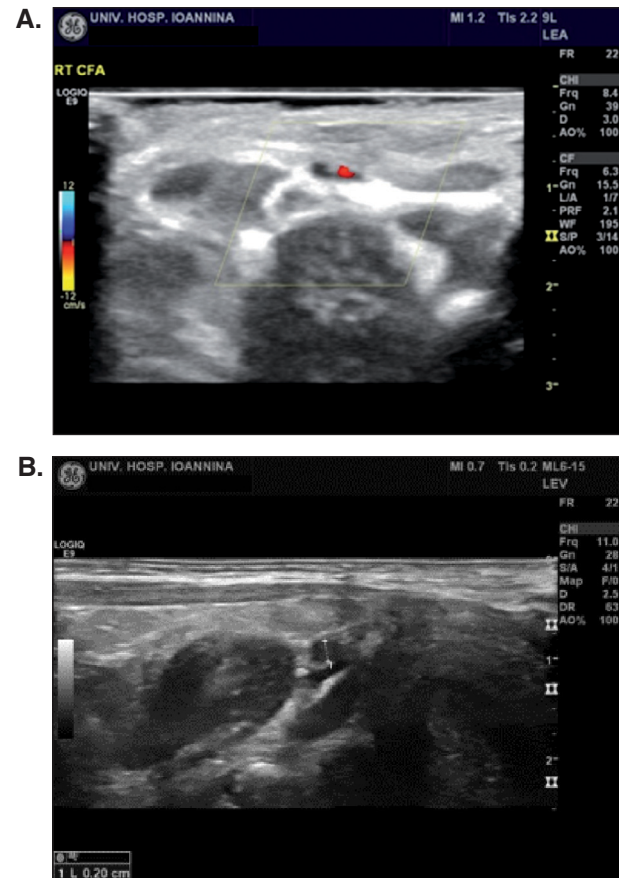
Sonographic images of neonatal femoral artery thrombosis. A. No blood flow in the right common femoral artery (CFA). B. Clot at the right CFA causing a blockage of the blood flow.
